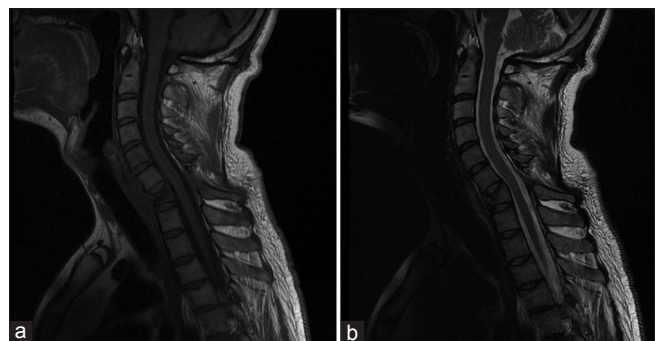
The T1-weighted (a) and T2-weighted (b) sagittal Magnetic resonance imaging of the cervical spine of the patient demonstrating the flexion-distraction injury of the C7 vertebra with rupture of the ligamentum flavum and interspinous and supraspinous ligaments. There is no sign of cervical spinal cord signal change
